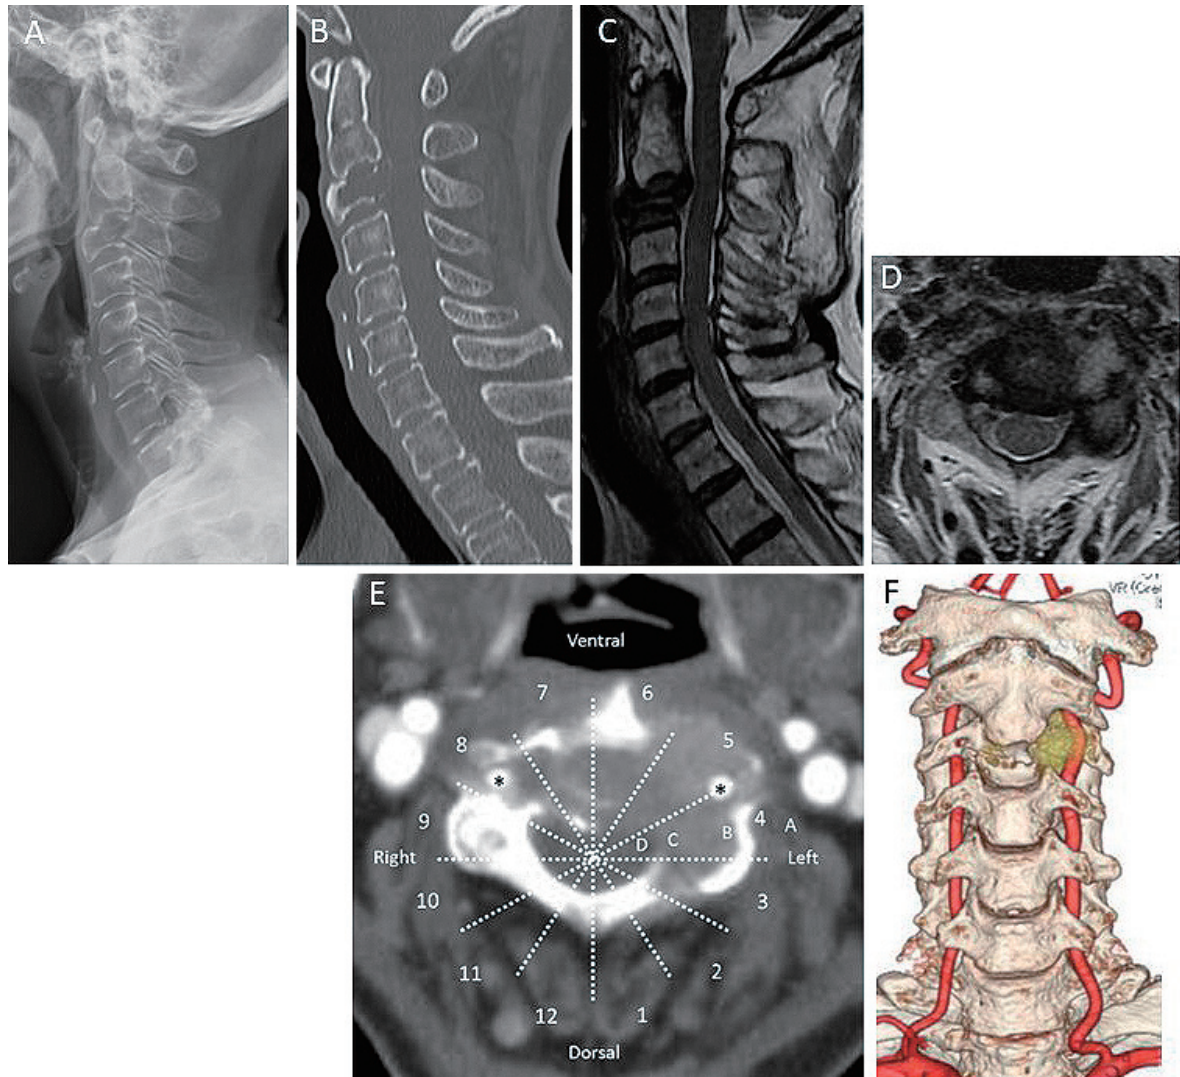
Preoperative images of the cervical spine. A, B: Preoperative plain X-ray and computed tomography (CT) showing the osteolytic lesion of the C3 vertebral body. C, D: Preoperative T2-weighted magnetic resonance imaging (MRI) showed a tumor formation in the C3 vertebral body with minimal compression to the spinal cord. E, F: Preoperative CT with contrast showing the osteolytic lesion of the C3 vertebral body completely encasing the vertebral artery on the left side. The tumor was distributed to layers A–D, sectors 3–8 based on the Weinstein–Boriani–Biagini staging. Zone A begins at the junction of the osseous spine and the surrounding soft tissues, Zone B involves the bone superficially, Zone C involves the bone closer to the spinal canal, and Zone D begins at the junction of the osseous extent of the spinal canal and the epidural space. Please note the vertebral artery (*).
